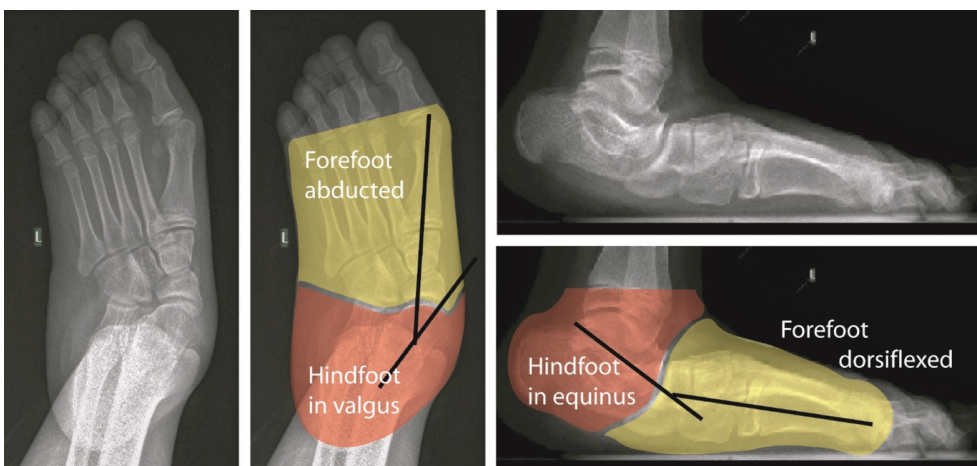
Forefoot abduction and forefoot dorsiflexion associated with equinus and valgus of the hindfoot and a mid-foot break seen on weight-bearing radiographs of an adolescent with cerebral palsy.
